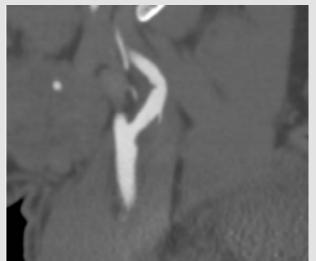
Case 2, right carotid thrombus at CT angiography.
